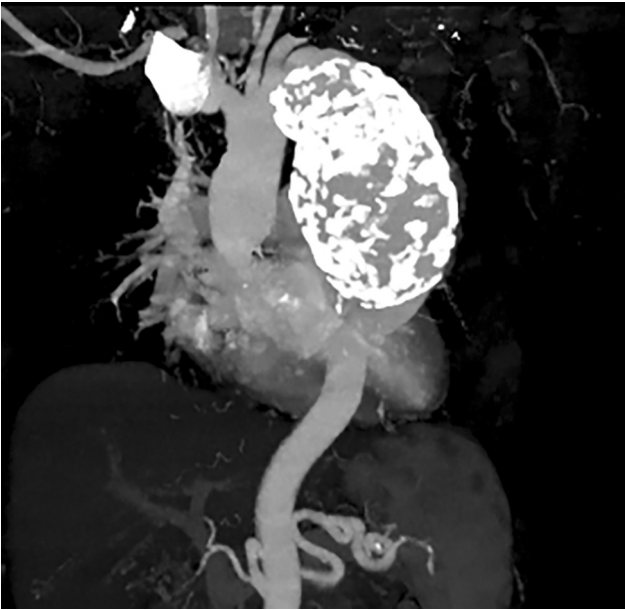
Computed tomography angiography reconstruction showed a giant aneurysm of the descending aorta with obvious calcification at the aneurysm wall.
